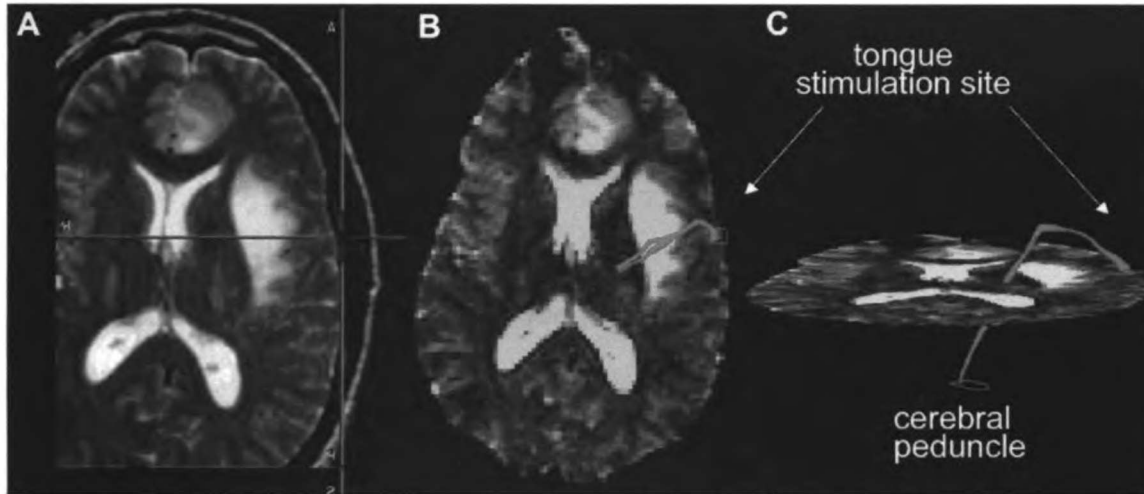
Fiber tracking from stereotactically identified motor site. A) Surgical navigation screen save of a tongue motor site in patient 11. The center of the cross-hairs indicates the position of the tip of the stereotactic probe on T2-weighted FSE MR images. B) The corresponding axial echo planar image from the DTI set with the square starting region (arrow) and 3D fiber tracks (red). C) Coronal projection of fiber tracks connecting the cortex with the cerebral peduncle. The outline of the region drawn in the cerebral peduncle for filtering the fiber tracks is shown.
